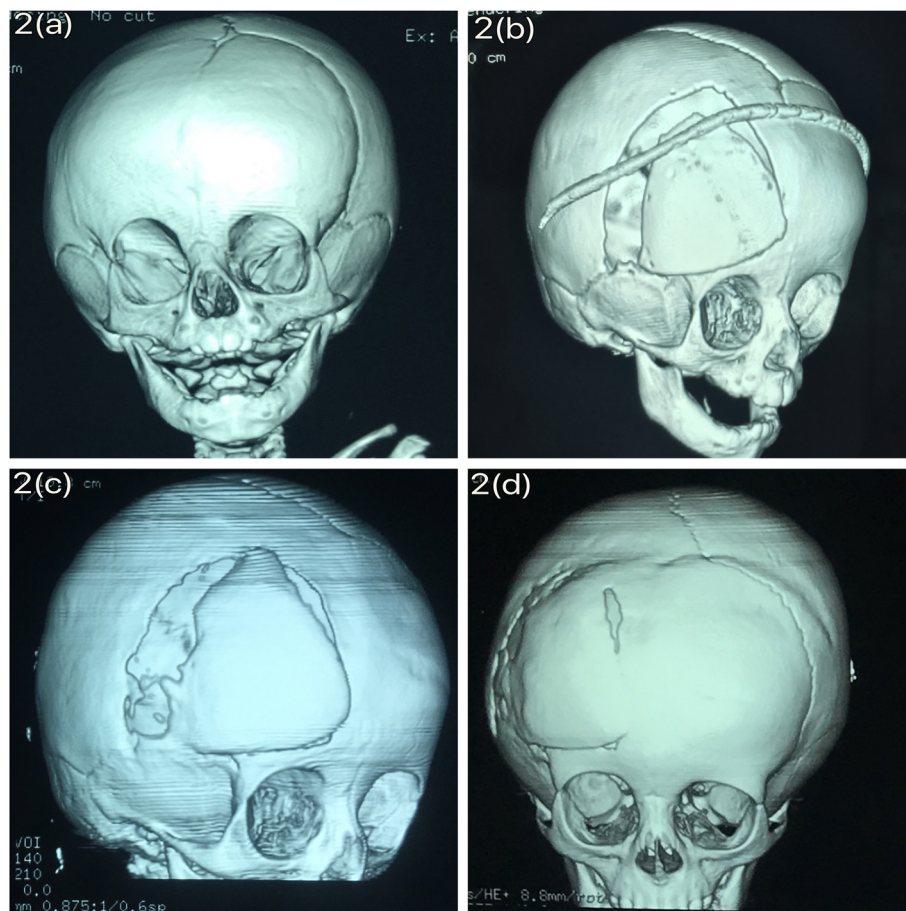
a) 3D skull reconstruction CT showing right anterior Plagiocephaly b) immediate postoperative image showing the rotated overlapped frontal flap c) 3 months postoperative image d) 1-year postoperative image showing bone remodeling and bone regrowth in the defect
